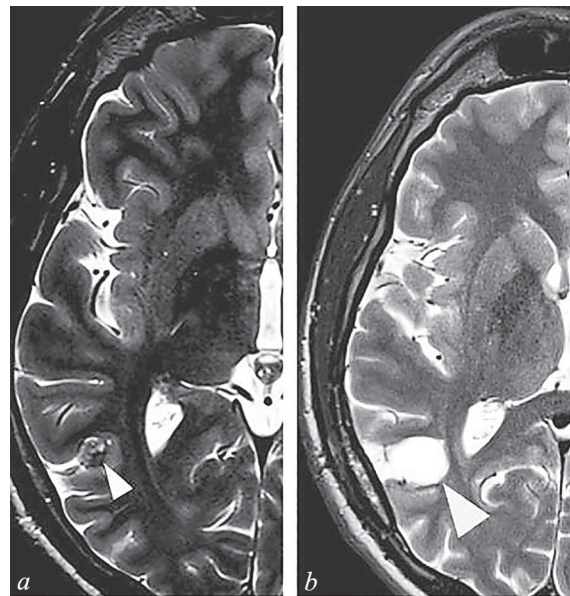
Axial MRI scan. *a*) T2-weighted high-resolution image (preoperative); *b*) T2-weighted image (postoperative).
